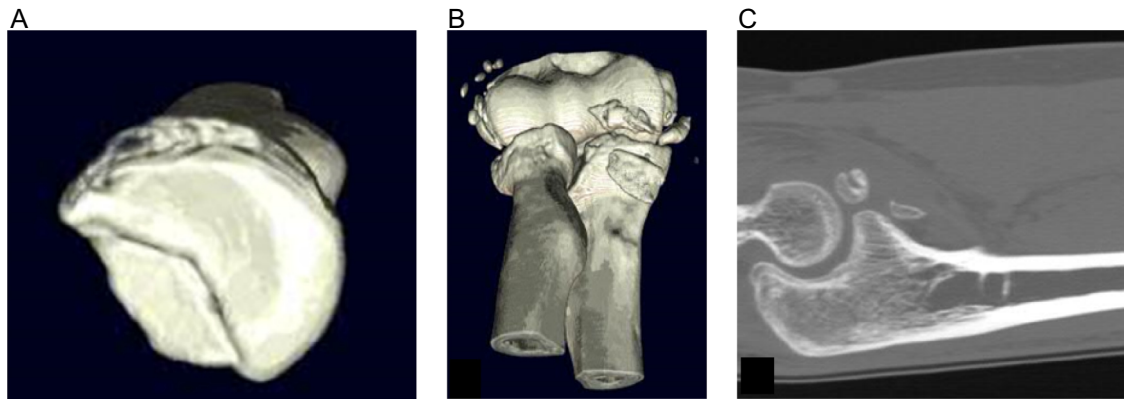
(A) A 3-dimensional computed tomography (CT) reconstruction showing the initial radial head defect involving 40% of the articular surface. (B) A 3-dimensional CT reconstruction showing an anteromedial subtype 2 coronoid fracture. (C) Sagittal CT cut demonstrating coronoid deficiency. (Used with permission of Mayo Foundation for Medical Education and Research. All rights reserved.)
